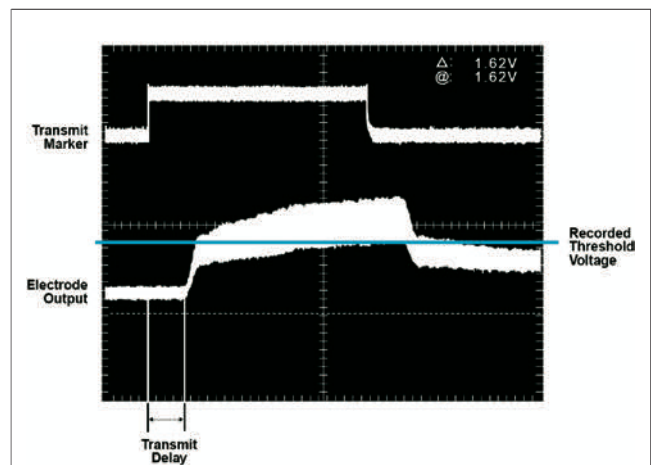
Ultrasound-Mediated Pacing Threshold
